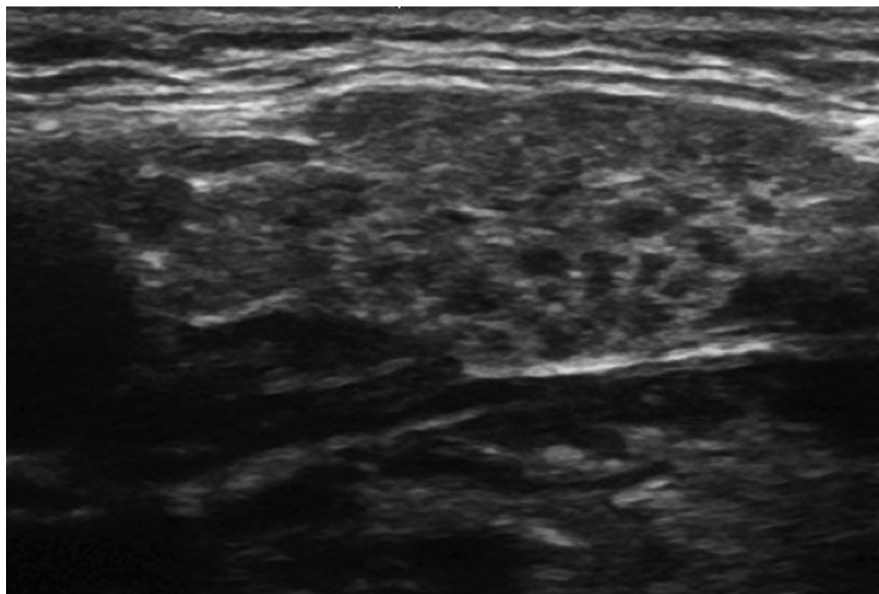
Longitudinal ultrasound image of a submandibular gland showed multiple hypoechoic areas in the gland parenchyma.
